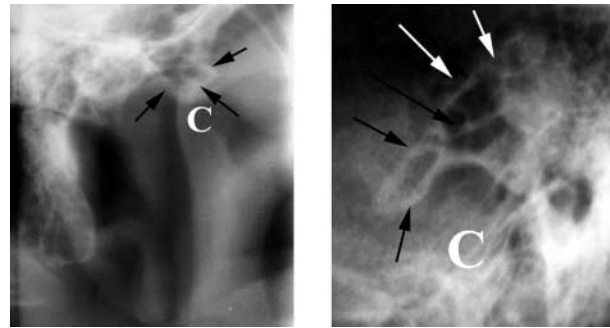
Portion of panoramic radiographies showing extensive multilocular pneumatization of the articular eminence. C, the mandibular condyle
